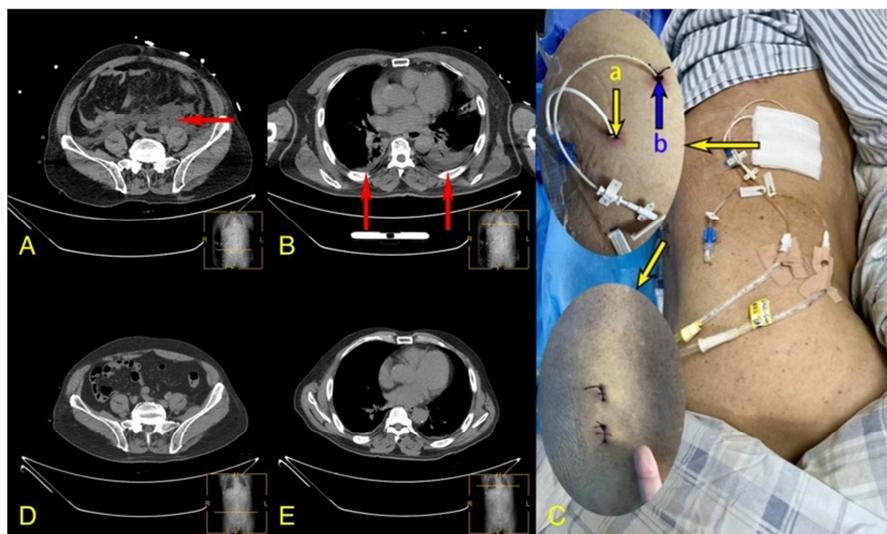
A. CT scan of whole abdomen: shows a large amount of fluid density in the retroperitoneum, abdominal cavity, and pelvic cavity (arrow points). B. Thoracic CT scan: small bilateral pleural effusion. C. Patient's access port and surgical port condition on postoperative day 3. Yellow arrows point to the first drain at point a and blue arrows point to the second drain at point b. D. CT scan of the whole abdomen revealed disappearance of fluid density in the abdominopelvic cavity and retroperitoneum. E. Chest CT scan showed bilateral pleural effusions almost disappeared.
